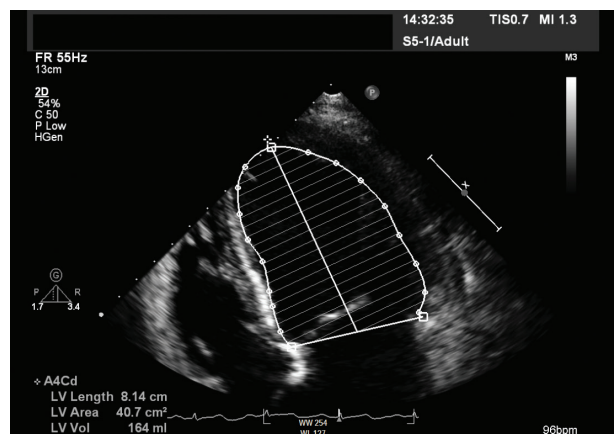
Pre-treatment echocardiogram shows a moderately dilated left ventricle with an end-diastolic volume of 164 ml.
